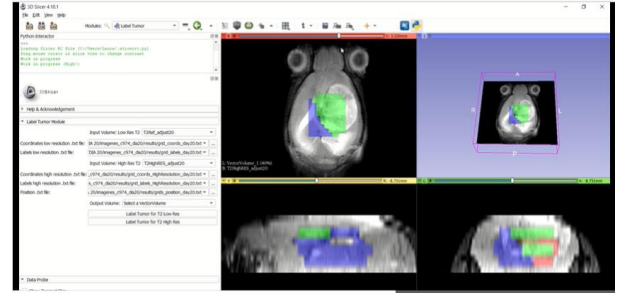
Screenshot of the preliminary version for 3D-MRSI visualisation launched. Left, menu for uploading files. Right, different views of the acquired MRI (horizontal, sagittal, coronal) with the MRSI-based nosological image of therapy response [3,4,5] superimposed in colour.
